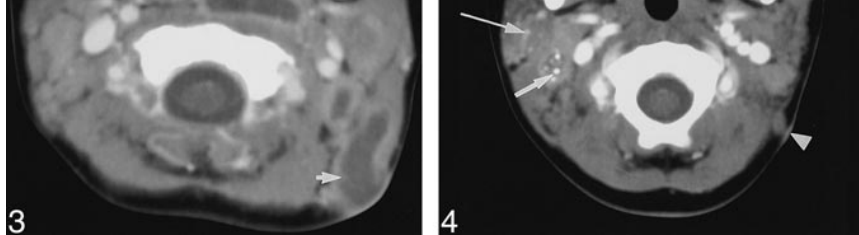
Case 10: Girl, two years nine months old, with right parotid and right cervical adenopathy. Axial contrast-enhanced CT scan demonstrates punctate calcification within low-attenuation ring-enhancing lymph node (arrow), posterolateral to right internal jugular vein. Calcification within right intraparotid adenopathy (long arrow) is visible. Two foci of left-sided skin thickening (arrowheads) adjacent to adenopathy are present.
